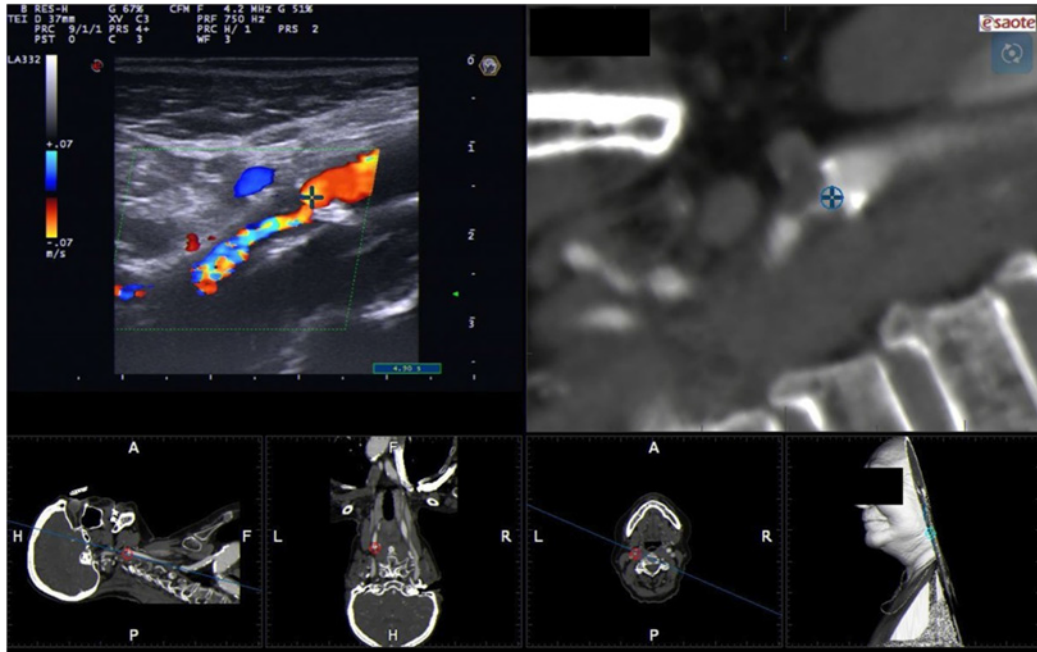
Top left: extracranial longitudinal insonation of a high-grade carotid stenosis. Top right: corresponding matched CT angiographic image.
